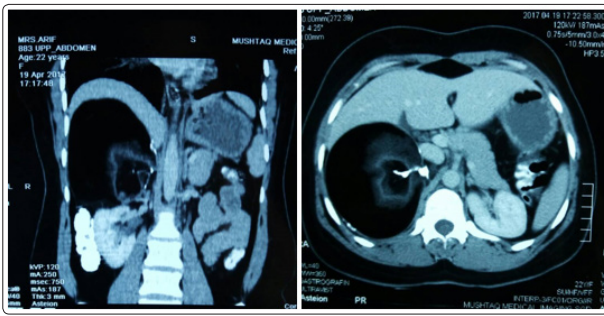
Axial and sagittal sections of CT scan KUB showing right sided dermoid cyst of right adrenal gland with central zone of calcification
